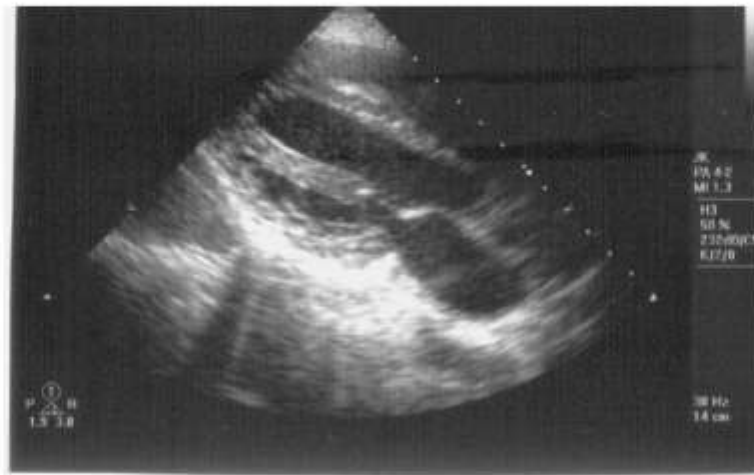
Trans-thoracic echocardiographic image, taken from the parasternal, long-axis view. Note the isolated hypertrophy of the anterolateral papillary muscle.
